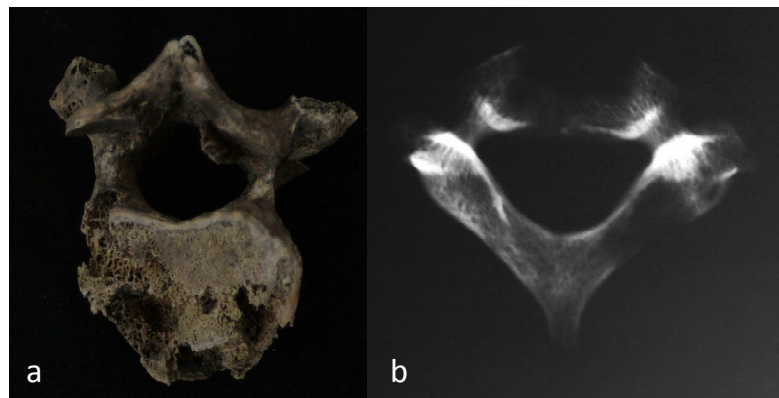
Osteolytic lesions in vertebrae: (a) thoracic vertebra – inferior view, displaying multiple lesions with variable sizes in the vertebral body; (b) radiograph of a cervical vertebra (superior view) with lytic lesions in the vertebral body and the neural arch.
